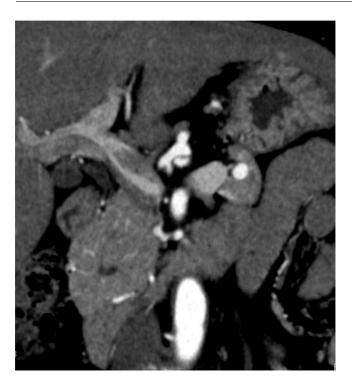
The CTA image of the distal side of the common hepatic artery. The dorsal pancreatic artery branches dorsally from the common hepatic artery.
